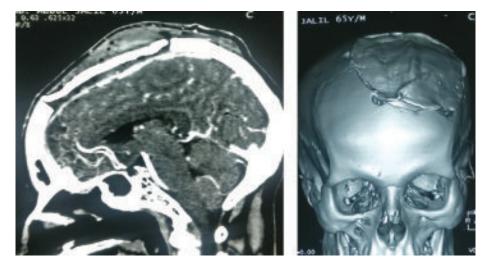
Pos-operative CT scan of brain showing no residual tumor and acceptable cranioplasty.
